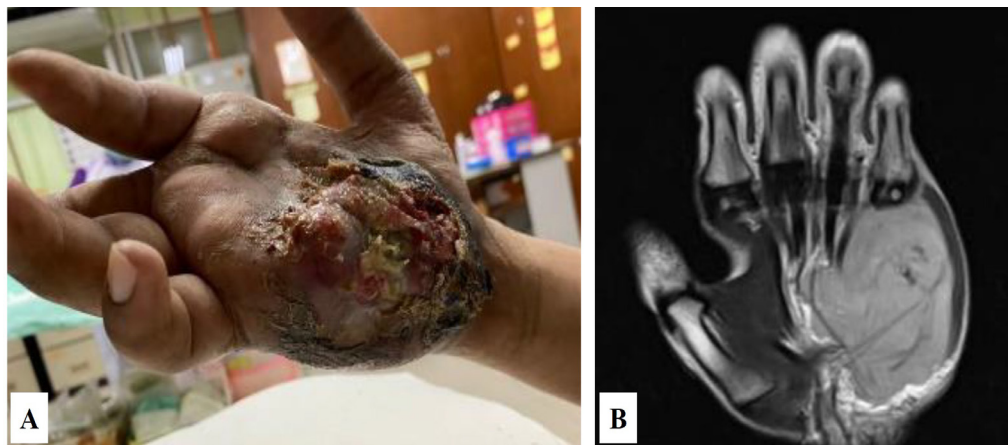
Case 1 (A) A fungating and ulcerated soft tissue mass over the hypothenar region of the right hand; (B) Coronal T1-weighted MR image showing a lobulated, homogeneous lesion involving the hypothenar muscles.
